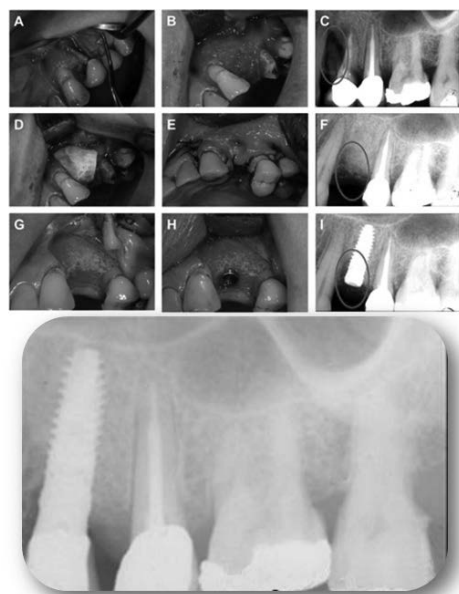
A, B, C) Bone defect visions and radiography (C) where bone defect is visible by black color; (D, E) granulated SB grafting; (F) radiography that underlines new bone formation 4 months after grafting procedure; (G) 4 months after implantation good tissue regeneration and osteointegration are observable; (H) screws for dental implants fixation to the new bone 4 months after scaffold implantation; (I) radiography after 8 months underlines bone regrowth and the possibility to fix on it screws for dental implants; (L) radiographic follow-up after 2 years proved robust evidences of good bone formation.
